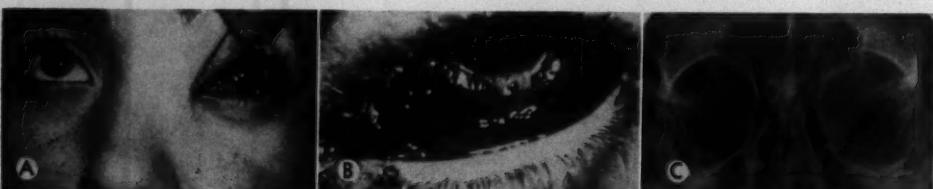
(Jones). Case 62. (A) Lymphangioma of orbit, conjunctiva and lids, with prominent hemorrhagic element. (B) Wartlike tumors on the conjunctiva and lids. (C) X-ray film, showing orbital enlargement in the same case.
